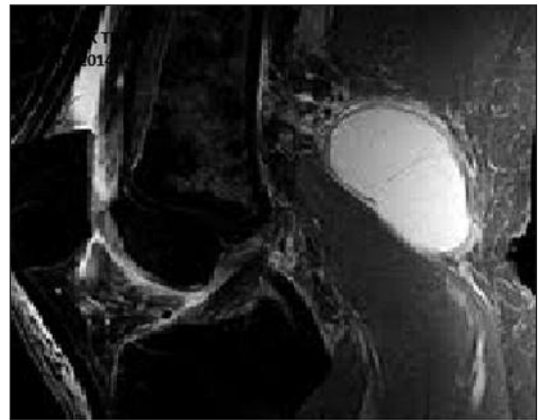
Popliteal venous aneurysm on magnetic resonance imaging. Sagittal T2 sequence of the popliteal venous aneurysm.
